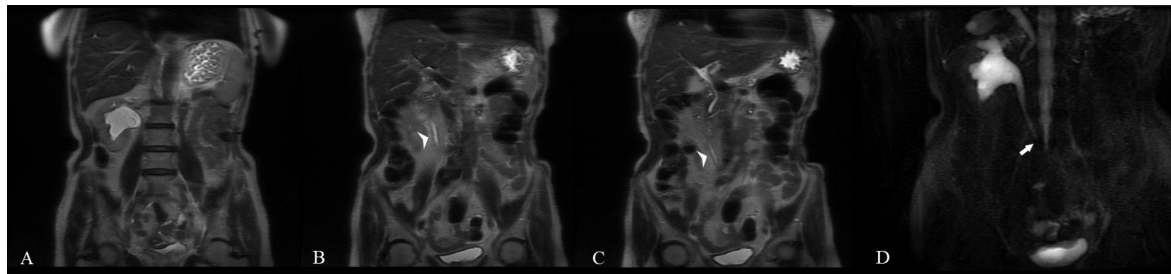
T2-weighted abdominal MRI scan showing right hydronephrosis (A) and progressive thickening of the right ureter (B,C) (arrowheads). Magnetic resonance urography showing the classic triad of retroperitoneal fibrosis: medial deviation of the ureter, tapering of the ureteral lumen (arrow), and hydronephrosis (D).
